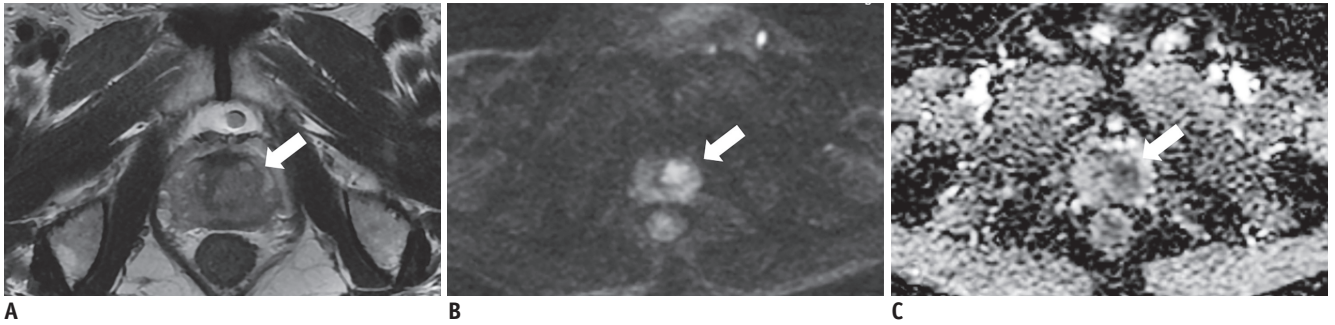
MRI report of this case was generated on free text basis of report A.
